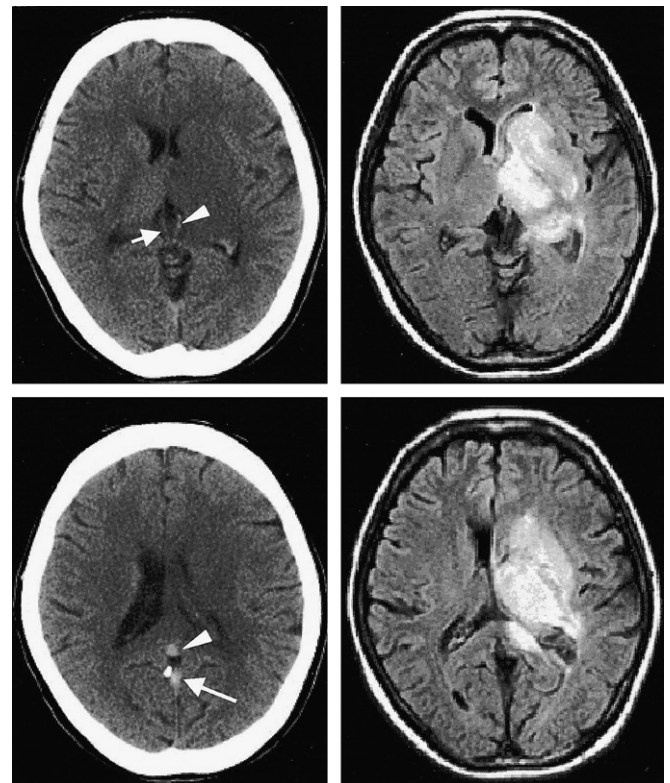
Left: a CT scan taken on admission, showing oedema in the left basal ganglia. The density of the left internal cerebral vein (arrowhead) is higher than that of the right (arrow) (left upper panel). The densities of the straight sinus (arrow) and the vein of Galen (arrowhead) had become higher than that at the first examination (left lower panel). Right: T<sub>1</sub>-weighted fluid attenuated inversion recovery MRI clearly revealed a high-intensity lesion.
